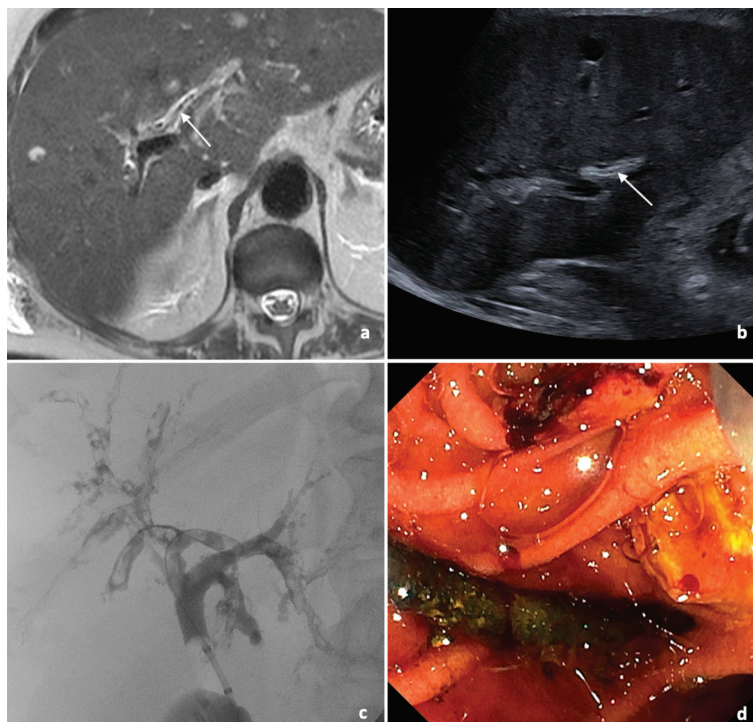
a) MRI cholangiography: suspicion of a biliary cast, as a white hyper-intense intrahepatic images on non-enhanced T1-weighted and a “duct-in-duct” image (arrow); b) Ultrasonography: confirmation of a “duct-in-duct” image (arrow); c) Endoscopic retrograde cholangiography: multiple biliary casts in bile ducts; d) Biliary casts and stones extracted from bile ducts during endoscopic retrograde cholangiography.
